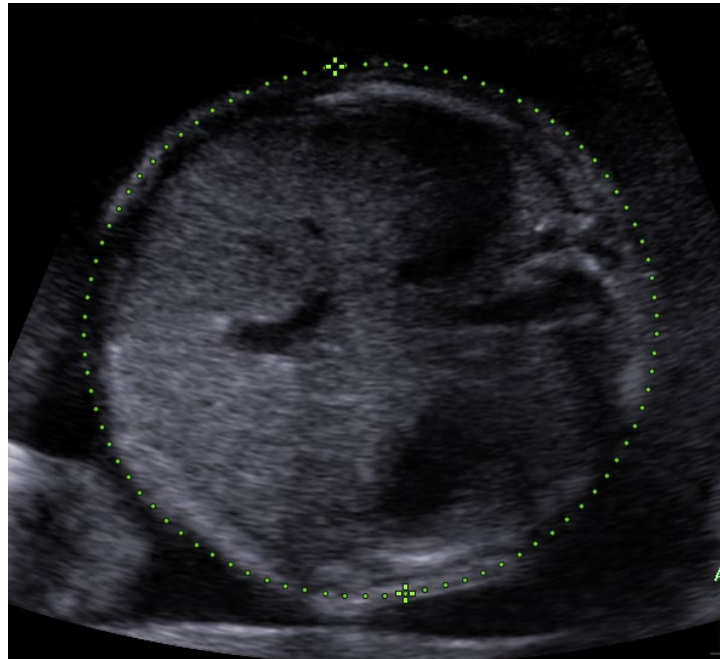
Ultrasound image of fetal abdominal circumference (AC). Participant image used with permission.
